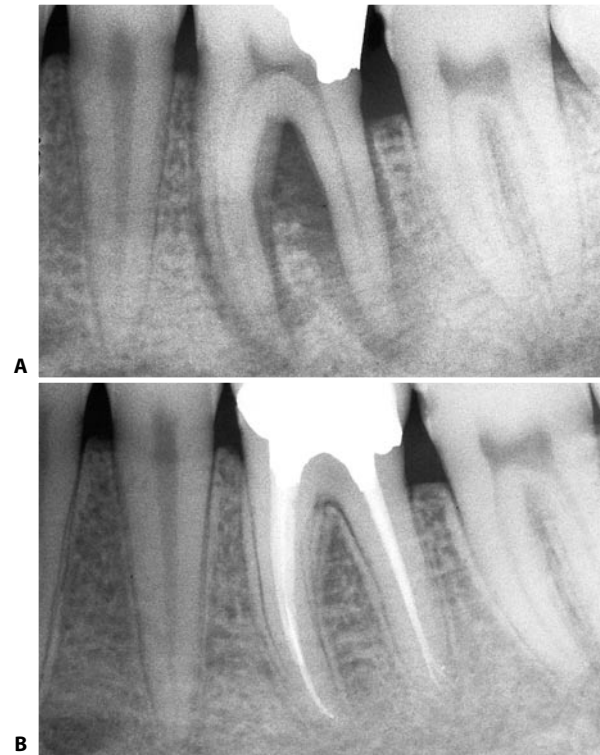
A. Preoperative radiograph of the lower left first molar. Note the radiolucency which completely surrounds the distal root and also involves the bifurcation. B. One year later. Note that an apical delta has been filled on the distal root. The radiopaque image in the apical third of the mesial root is due to filling of the confluence of the two canals.
